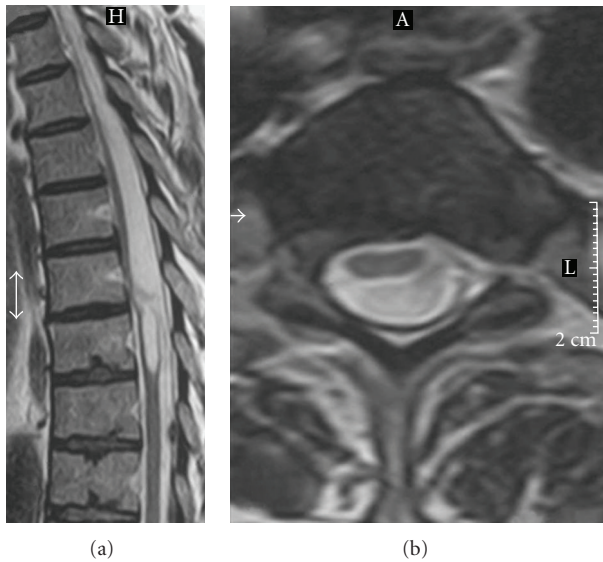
Preoperative T2 weighted MR images, sagittal (a), and axial (b) sections: the spinal cord is displaced anteriorly by the arachnoidal cyst. An associated caudal syringomyelic cavity at D8 is evident.
